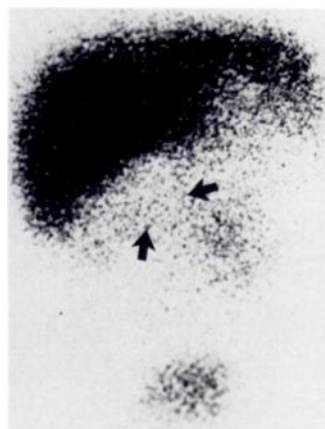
Neonatal hepatitis. Sonography showed enlarged gallbladder 3.5 cm in greatest length. Tracer activity in gastrointestinal tract (arrows) on ^{99m}Tc -DISIDA image. Normal hepatic extraction of tracer. Some activity within kidneys and bladder.
